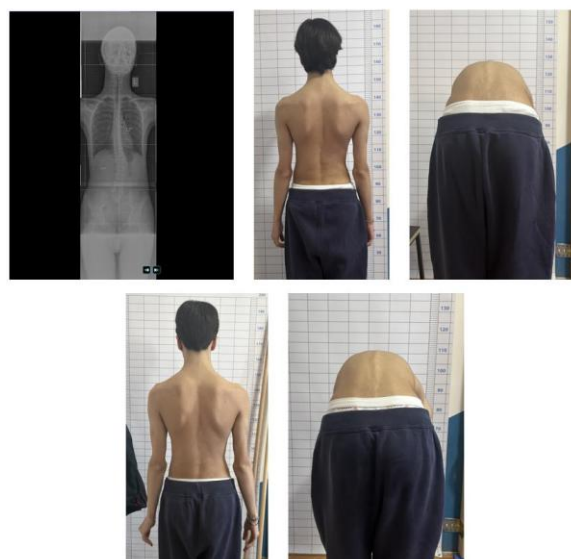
Radiographic and clinical improvement in a male patient with idiopathic scoliosis after PSSE-Schroth exercises
